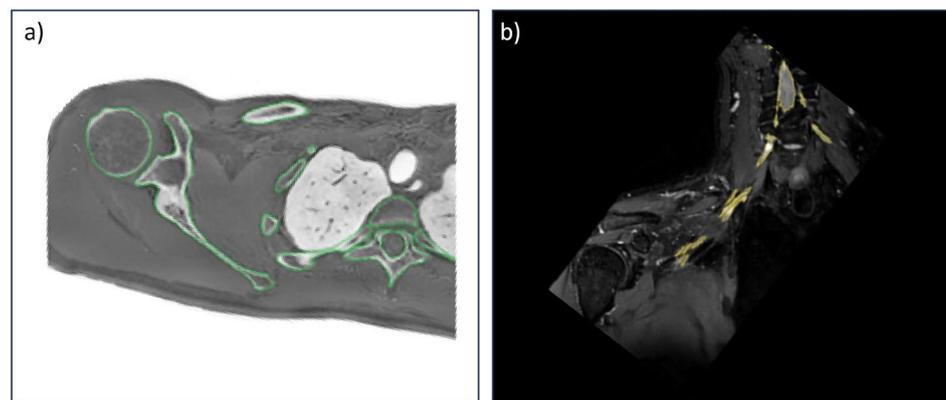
(a) A representative ZTE MRI axial slice shows the outlined bone segmentation (green) and (b) a representative MR neurography coronal slice demonstrates the highlighted nerve segmentation (yellow)
